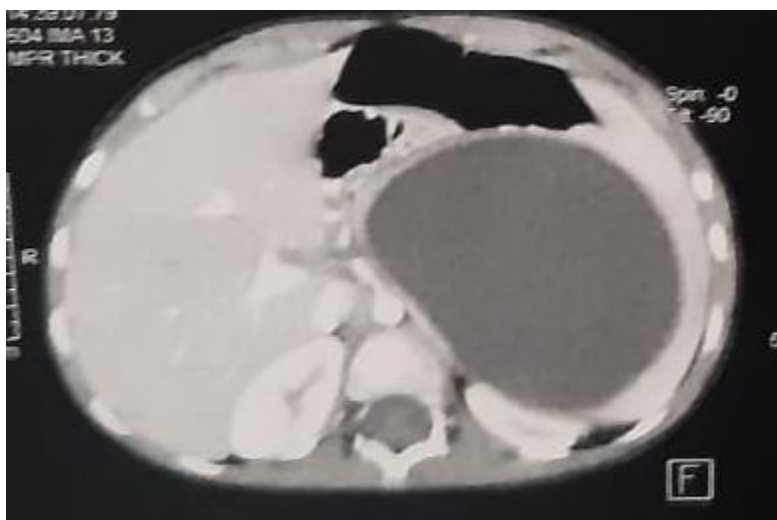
CT scan showing a geant splenic cyst
